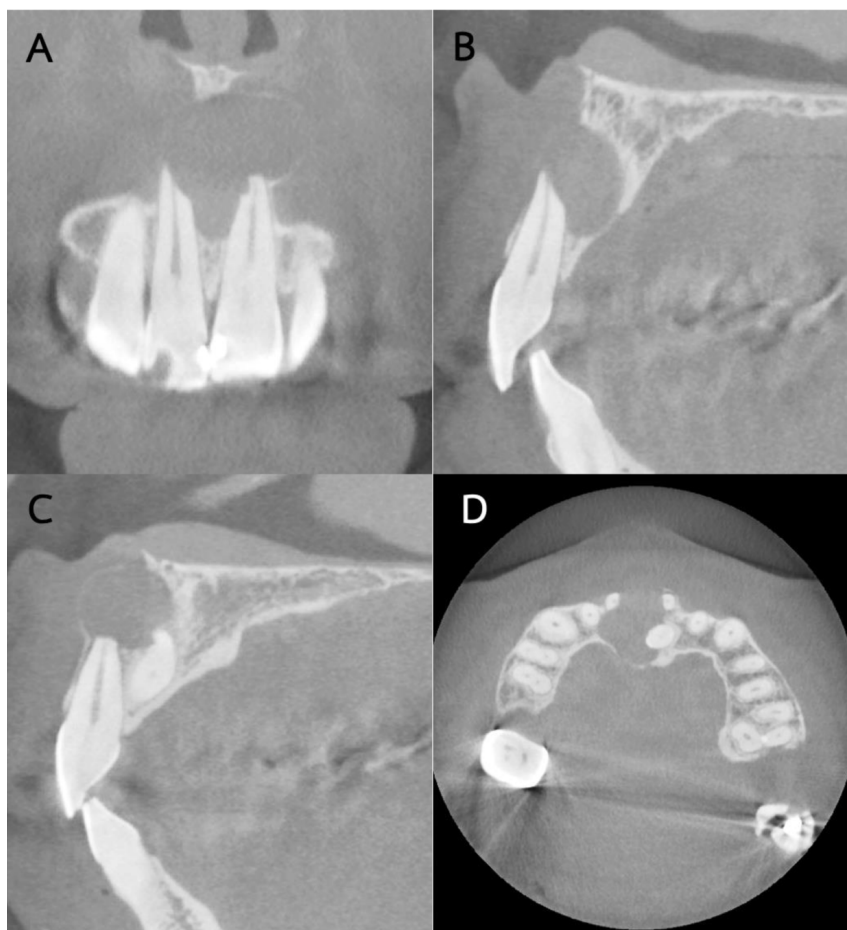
The cone-beam computed tomography images (A: Coronal view, B: Sagittal view of tooth 11, C: Sagittal view of tooth 21, and D: Axial view) show that the apices of teeth 11 and 21 are involved with the radiolucent lesion.
